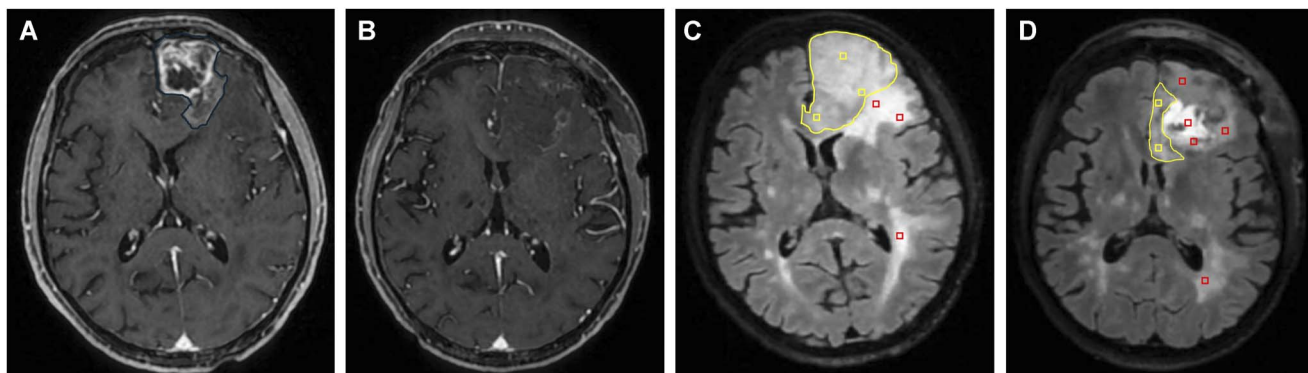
A and B, Manual segmentation based on T1 gad and C and D, FLAIR sequences for volumetric evaluation of high-grade gliomas. Contouring of presumed tumor infiltration on FLAIR images was performed by identifying differences in signal intensity found in the peritumoral areas, involving the placement of ROIs in regions with different signal intensities. As it is known, the brain area surrounding the contrast-enhancing tumor exhibits lower signal intensity compared with the more distant white matter, which displays a FLAIR signal intensity similar to the oedema observed in noninfiltrating tumors (ie, meningioma, metastases). Based on these imaging features and after confirming the different signal intensities using multiple ROIs, manual segmentation of the tumor edges was conducted independently by 2 neurosurgeons at each center, both with specific experience in neuro-oncology. C, In this case, the yellow ROIs revealed a lower hyperintensity value than 3 red ROIs peripherally placed. This allows to differentiate tumor (yellow ROIs), included in segmented areas, from edema (red ROIs) excluded from segmented lesion. D, Same method described above (multiple ROIs analysis of hyperintense areas) has also been applied to the postoperative FLAIR images. Hyperintense areas surrounding the surgical cavity are often extended beyond the margins of the preoperative FLAIR-positive areas due to the effects of vascular damage or surgical manipulation. However, in all these cases, the hyperintense signal is similar to that of oedema; therefore, these areas have been excluded from volumetric evaluation. FLAIR, fluid-attenuated inversion-recovery; ROI, region of interest.
